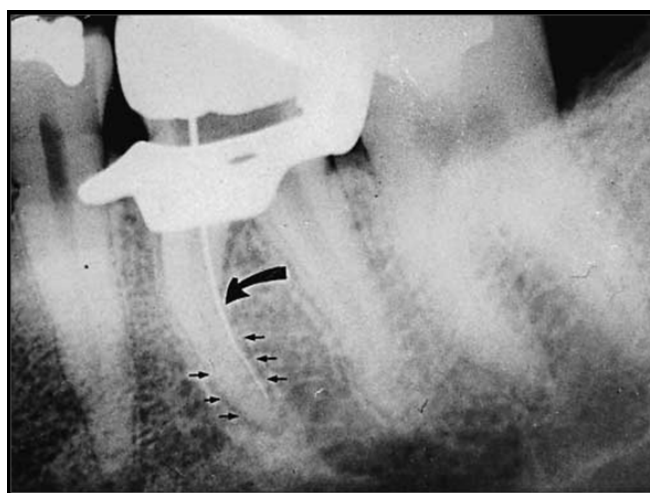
Radiograph indicating the presence of a second, or missed, canal. By following the lamina dura of the root (small arrows), the eccentric position of the file (large arrow), with relation to the outline of the root, suggests the presence of a missed canal. In this case, a perforation is confirmed: the file is in the periodontal ligament, and the mesial canals have not been negotiated.
